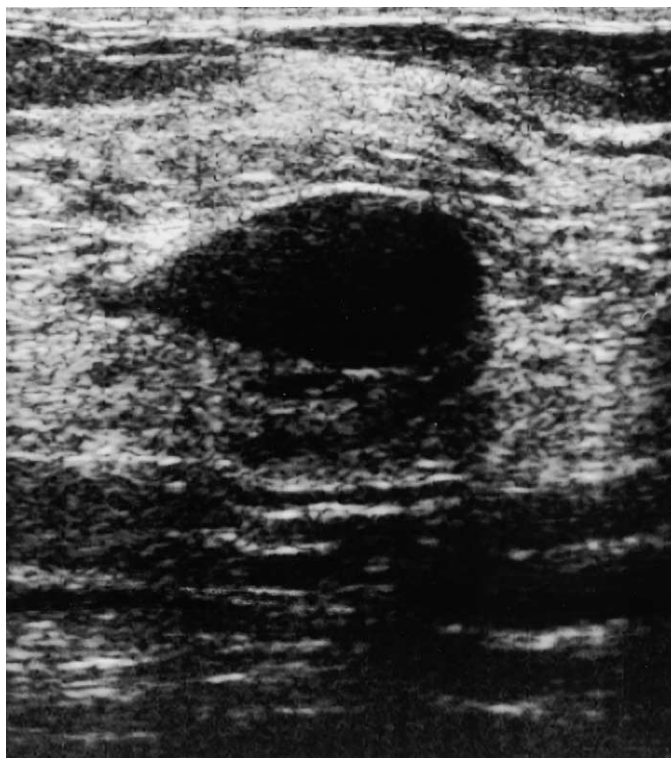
Biopsy-proven fibroadenoma at sonography. Note the circumscribed borders, oval shape that is wider than it is tall, and echogenic capsule. Minimal posterior acoustic shadowing is present.
